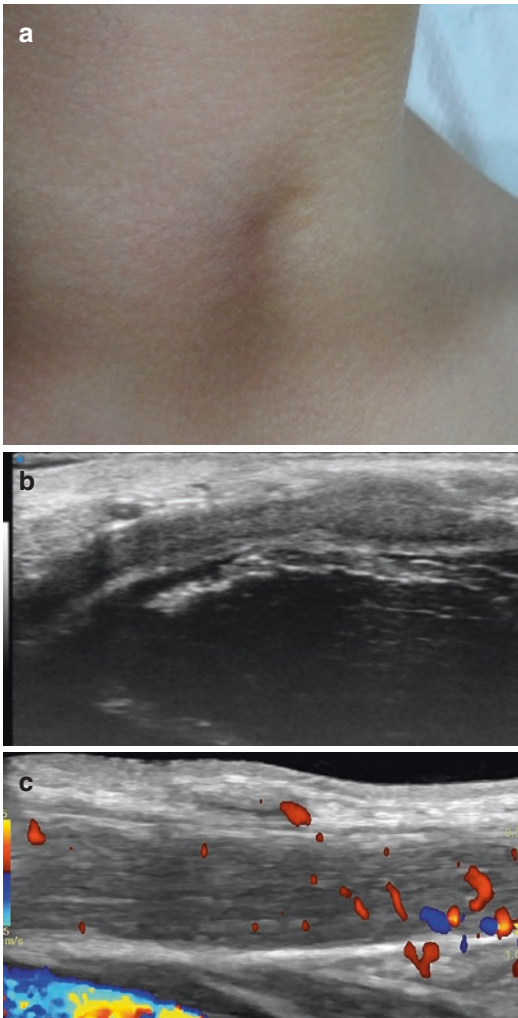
Branchial fistula. (a) Clinical picture. (b) Grayscale ultrasound (70 MHz) shows oblique hypoechoic subaponeurotic band attached to the surface of the left sternocleidomastoid muscle. (c) Color Doppler ultrasound (longitudinal view; 18 MHz) demonstrates some vessels in the periphery of the fistula but no signs of vascularity within the lesion. The sternocleidomastoid muscle is located underneath the fistula and presents some vascularity.
